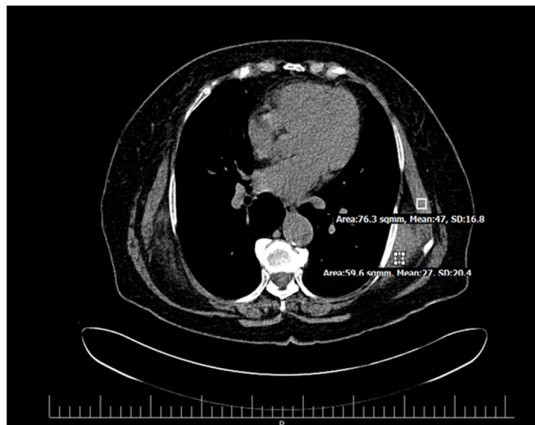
CT imaging of elastofibroma dorsi reveals bilateral soft tissue masses exhibiting attenuation comparable to that of adjacent muscles, interspersed with strands of fat, located deep to the serratus anterior and latissimus dorsi muscles.
